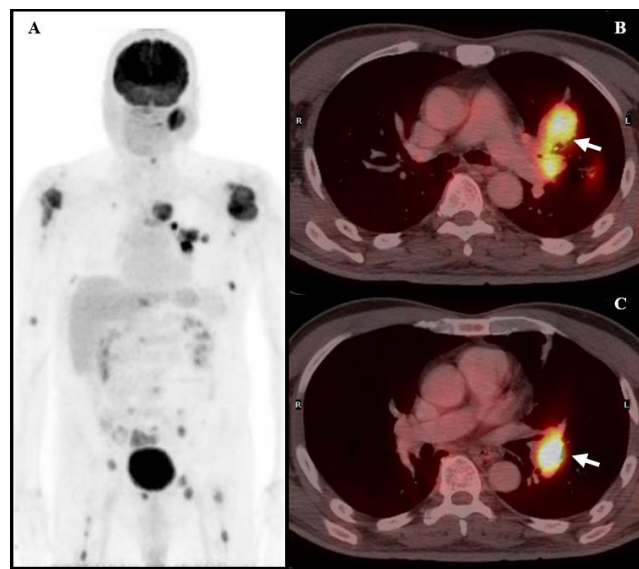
PET/CT scan (A) Maximum intensity projection image showed multiple hypermetabolic lesions throughout the body, (B) axial view of fused image showed a 3.4 cm. hypermetabolic lung mass at left upper lobe and (C) axial view of fused image showed a 2.4 cm. hypermetabolic left hilar lymph node.
